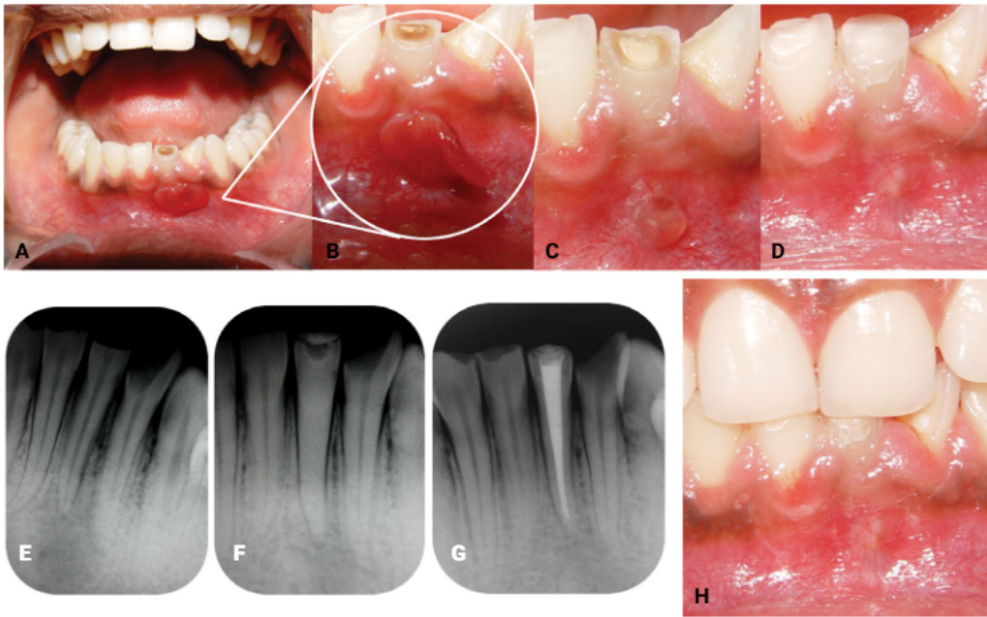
Case 1. (A) General visual inspection; (B) initial appearance of the lesion, close-up view; the appearance of the lesion after 15(C) and (D) 45 days with intracanal dressing maintenance of CPMC-enriched calcium hydroxide; (E) initial X-ray; (F) evidence of bone repair in X-ray 45 days later; (G) complete bone repair; and (H) healed lesion site 6 months later.
